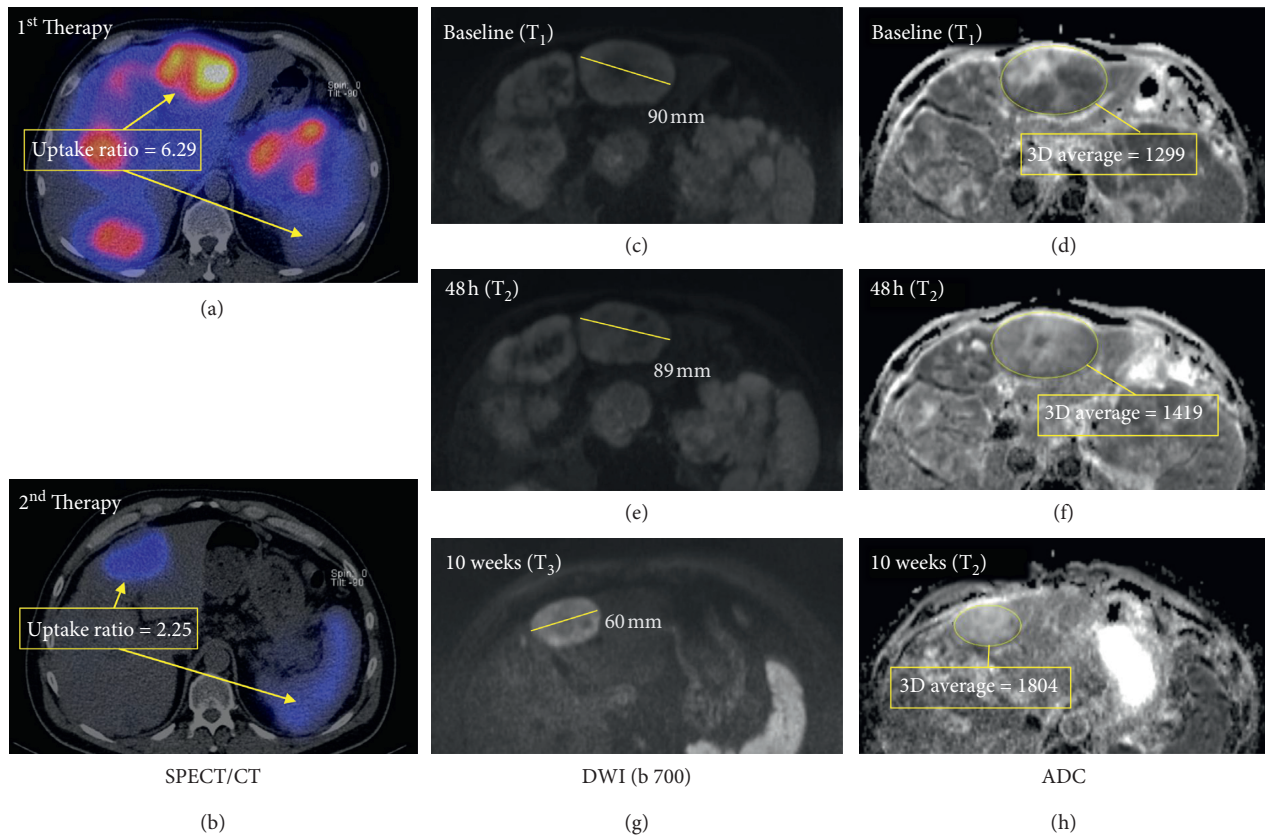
Cross-sectional imaging studies of a 53 y/o male with NET of pancreatic origin with hepatic metastases treated with two cycles of PRRT (195 mCi and 170 mCi of  $^{90}\text{Y}/^{111}\text{In}$  -DOTATOC). The patient responded well to the first therapy with SPECT/CT images (a, b) showing a markedly decreasing uptake ratio after the 2<sup>nd</sup> therapy as compared with the 1<sup>st</sup> treatment cycle. Correspondingly, the size of the lesions as documented by the  $b = 700$  s/mm<sup>2</sup> diffusion-weighted MR images (c, e, g) showed an important decrease in size 10 weeks after treatment. In the ADC maps (d, f, h), an increase is seen already at T<sub>2</sub>, 48 h after initiation of therapy as an early sign of treatment response.
